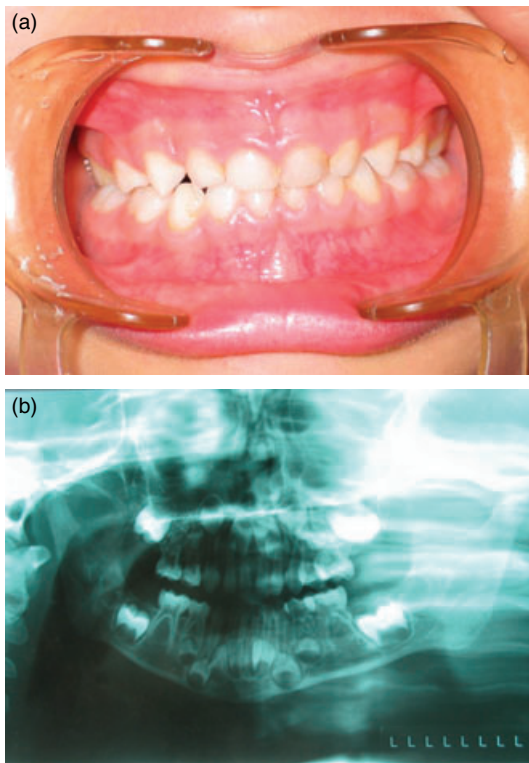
(a) Occlusal relation of the jaws in postoperative 6 months follow-up. (b) Postoperative sixth month panoramic X-ray of the patient shows the symmetric occlusal relation on both sides of the jaws.
